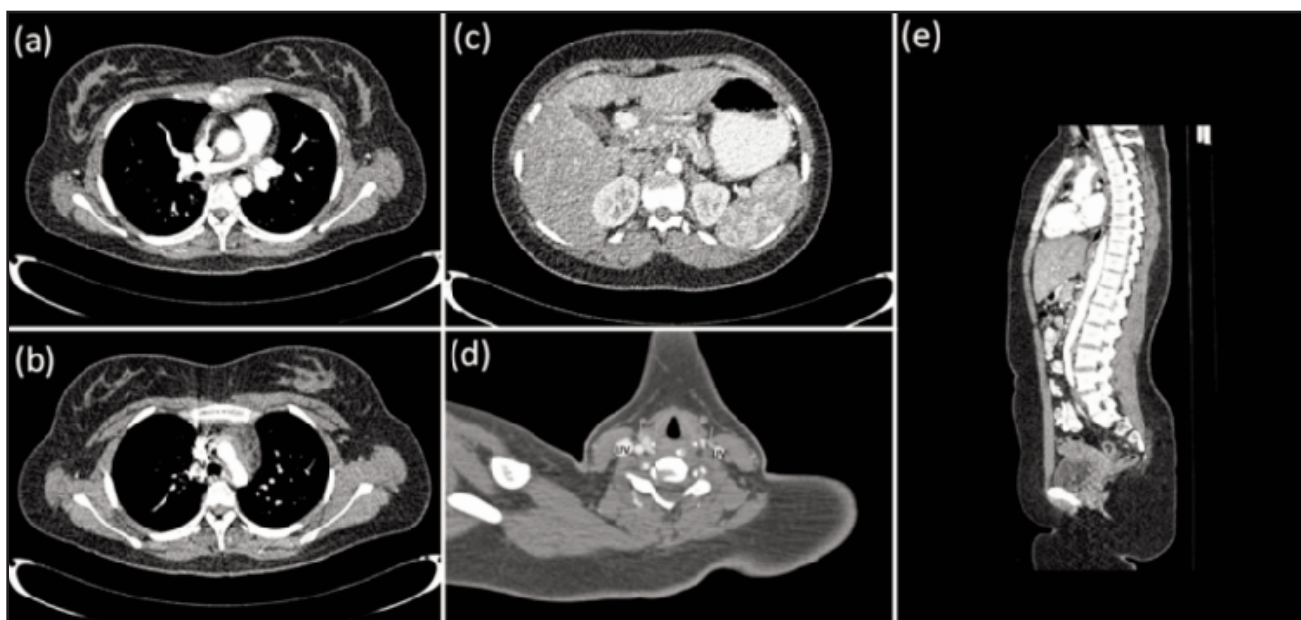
(a): CTA showed moderate circumferential wall thickening of right pulmonary artery with moderate luminal narrowing. (b): moderate arterial wall thickening at the arch of aorta. (c): proximal superior mesenteric artery is not well opacified in keeping with occlusion. (d) left internal carotid artery is not well opacified. (e)sagittal view of aorta showed luminal narrowing of celiac trunk and superior mesenteric artery.
